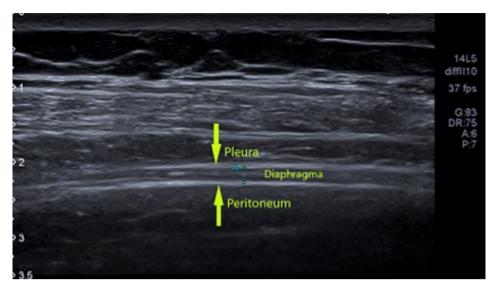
Ultrasound image of diaphragm muscle thickness
